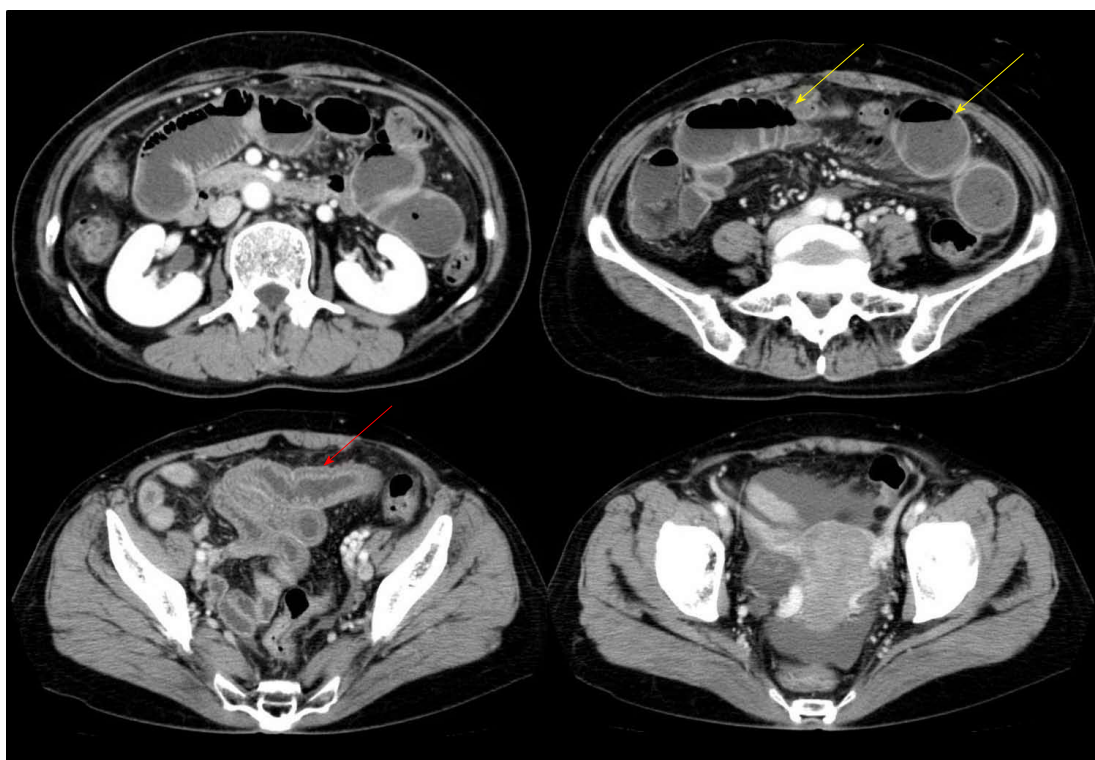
Abdominal computed tomography showing segmental edema of the intestinal wall (red arrow) with proximal dilatation (yellow arrow) and a small number of ascites.
